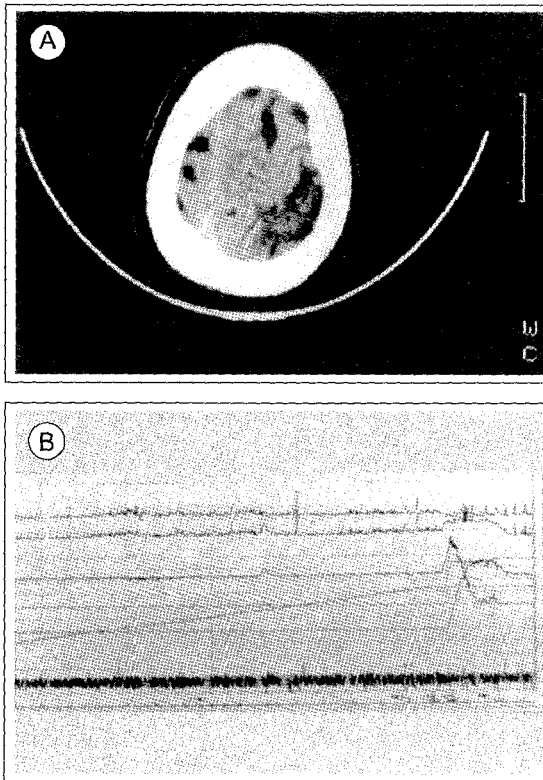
A: CT scan of a patient with a frontal lesion affecting the sphincteric area. B: Cystometrograms of the same patient showing involuntary low amplitude detrusor contraction with concomitant sphincter relaxation accompanied by leakage.
